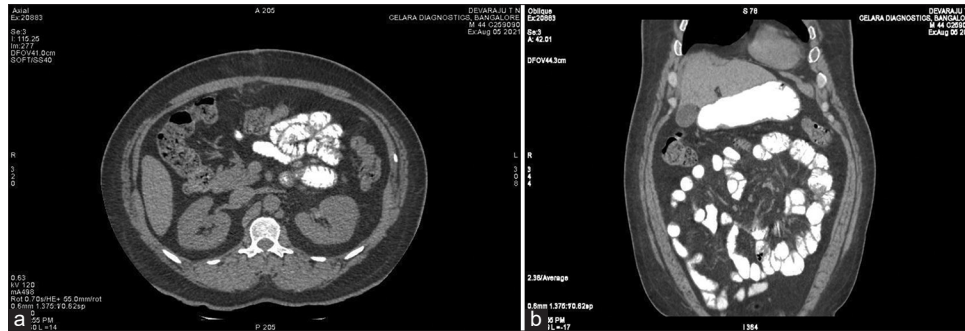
(a and b) Post operative computed tomography images showing no herniation
